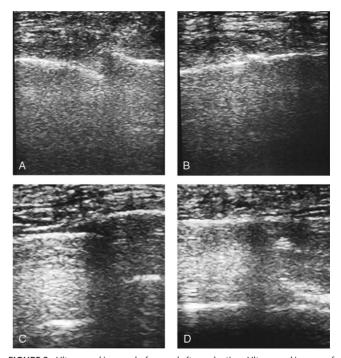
Ultrasound images before and after reduction. Ultrasound images of the inferior orbital rim before reduction (A) and after reduction (B), and the zygomatic arch before reduction (C) and after reduction (D).
